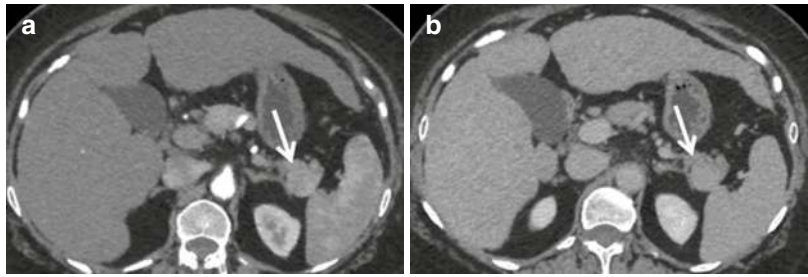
Incidental intrapancreatic spleen in the tail of the pancreas on CT. (a) Arterial and (b) venous phases showing an enhancing lesion in the tail of the pancreas (white arrows). Lesion shows enhancement similar to the spleen in both phases. Note the patient had chronic liver disease
